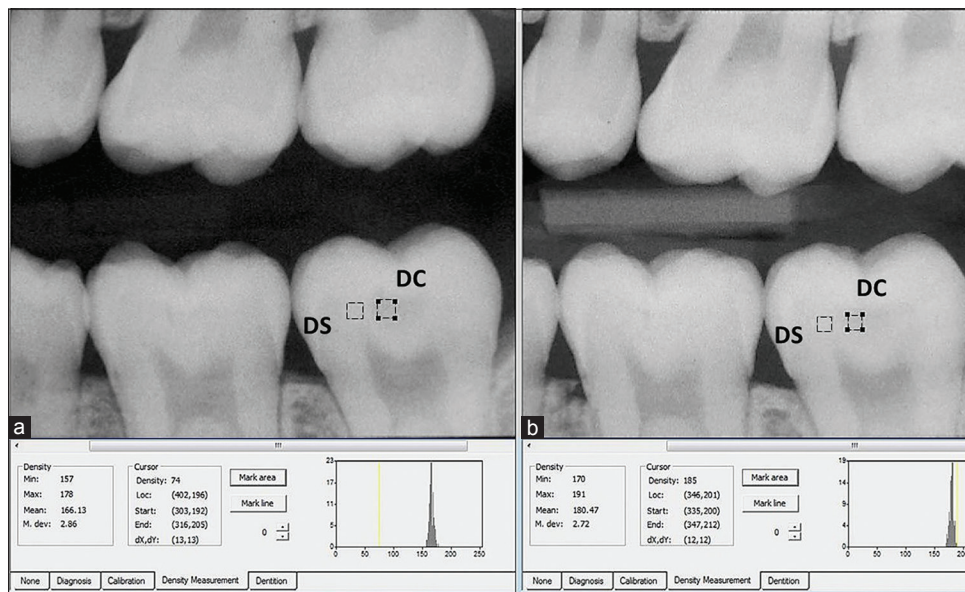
Method for obtaining the radiography density for healthy dentin (DS) and carious dentin. Marked areas show the healthy dentin and caries lesion at baseline (a) and the end of the study (b) (12 months). (3.8X)
